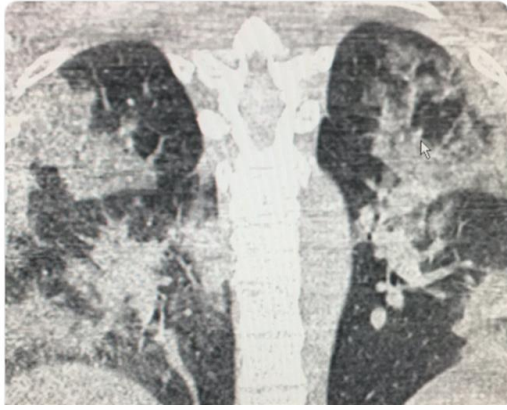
CT-Lung: 85 % of cases: GGO, bilateral infiltrations, increase of interstitial markings
